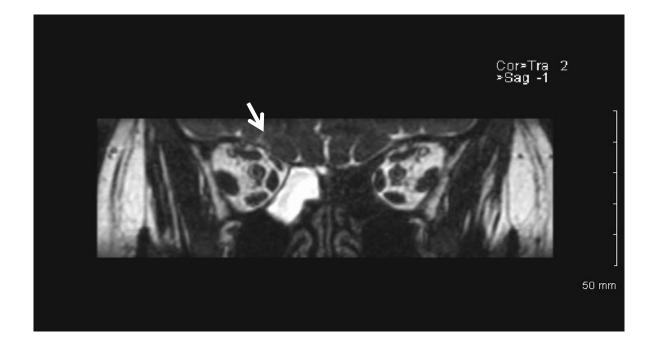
MRI coronal view of the suspected communication of the CSF; descending from the olfactory bulb to the medial wall of the right ethmoid sinus, which is filled with fluid signal. Suspected defect size is approximately 0.8mm.
